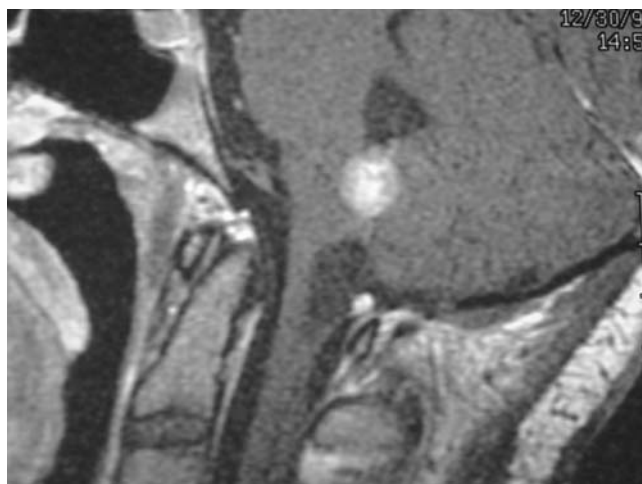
T1 sagittal contrast enhanced MRI of 19 year old with two hemangioblastomas (patient 1)
